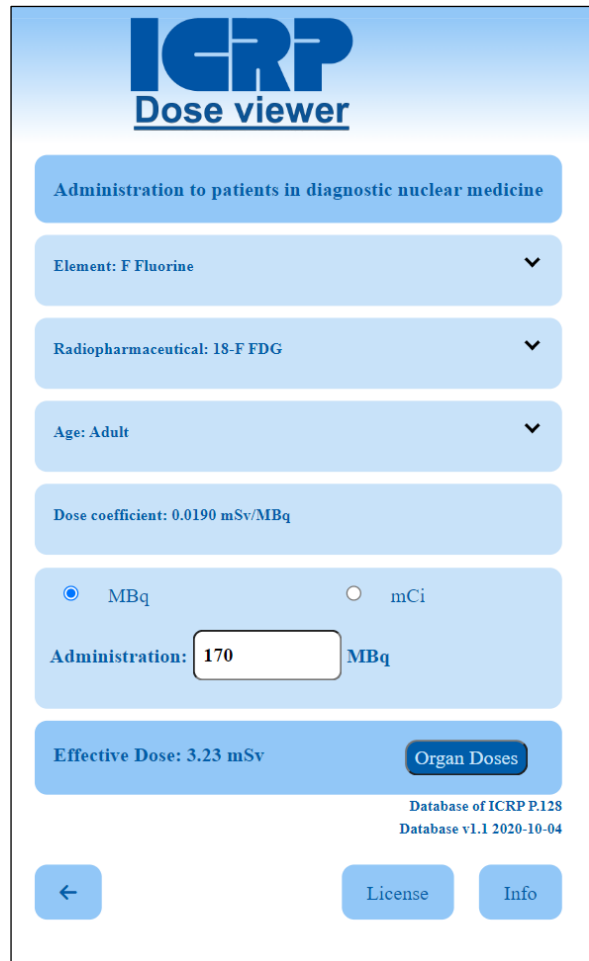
The image shows the effective dose coefficient for an adult and also the corresponding effective dose for an injection of 170 MBq of ¹⁸F-FDG.
